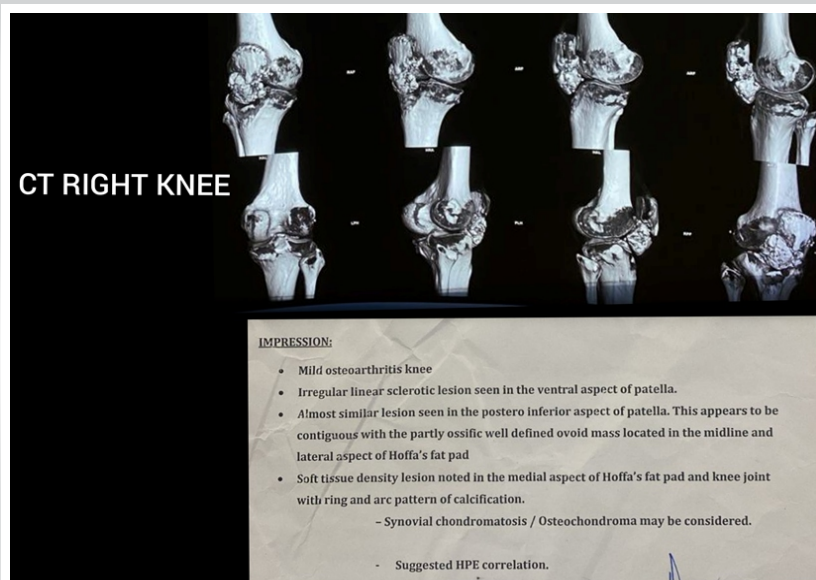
Computed tomography scan.
